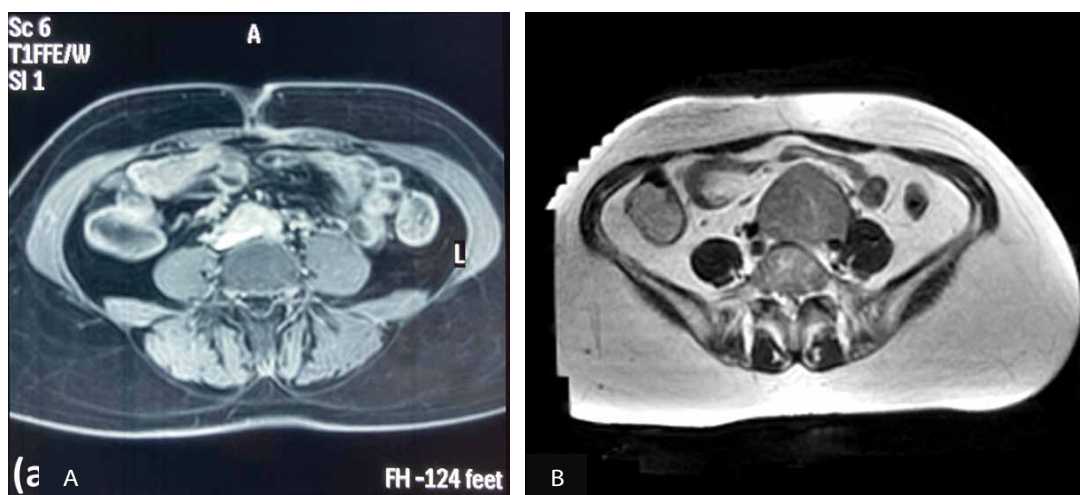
(A) Abdominal MRI two months postoperatively, showing residual tissue near the aortic bifurcation. (B) At her last follow-up, abdominal MRI indicates relapse of her tumour.
